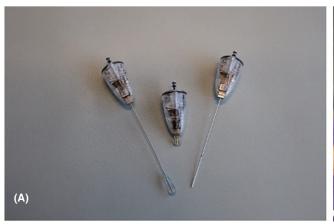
(A) Needle tips from handheld cryoneurolysis devices. (B) FDA-approved handheld cryoneurolysis devices used in combination with ultrasound-guidance. Courtesy of I over.
